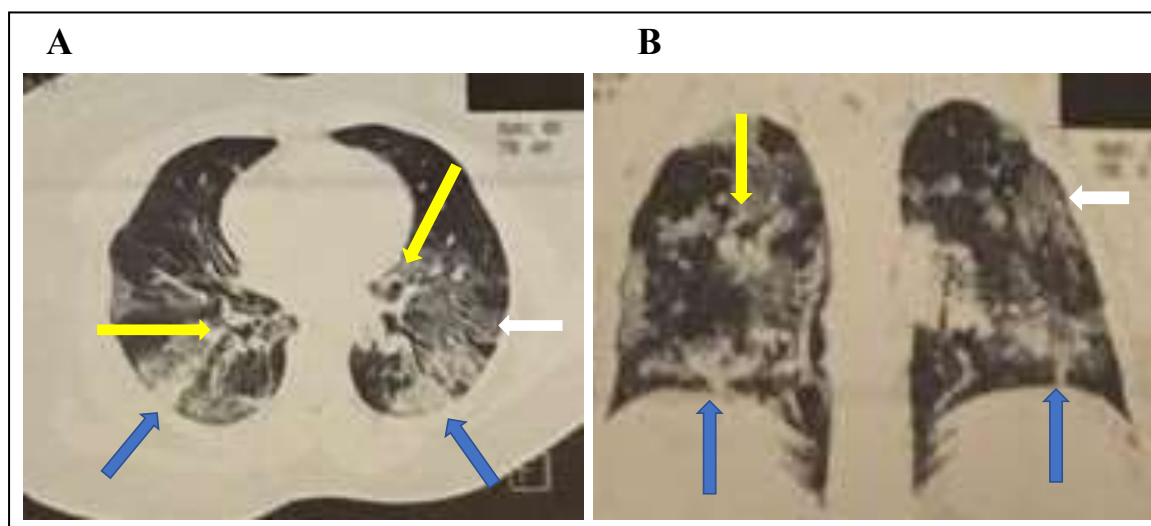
chest CT scan revealing a severe form of COVID-19 pneumonia with lung damage ranging between 60-70%. The images (A and B) show foci of parenchymal consolidation (blue arrows) associated with ground glass (white arrows), bilateral, predominantly at the lung bases and complicated with cylindrical bronchiectasis (yellow arrows).
